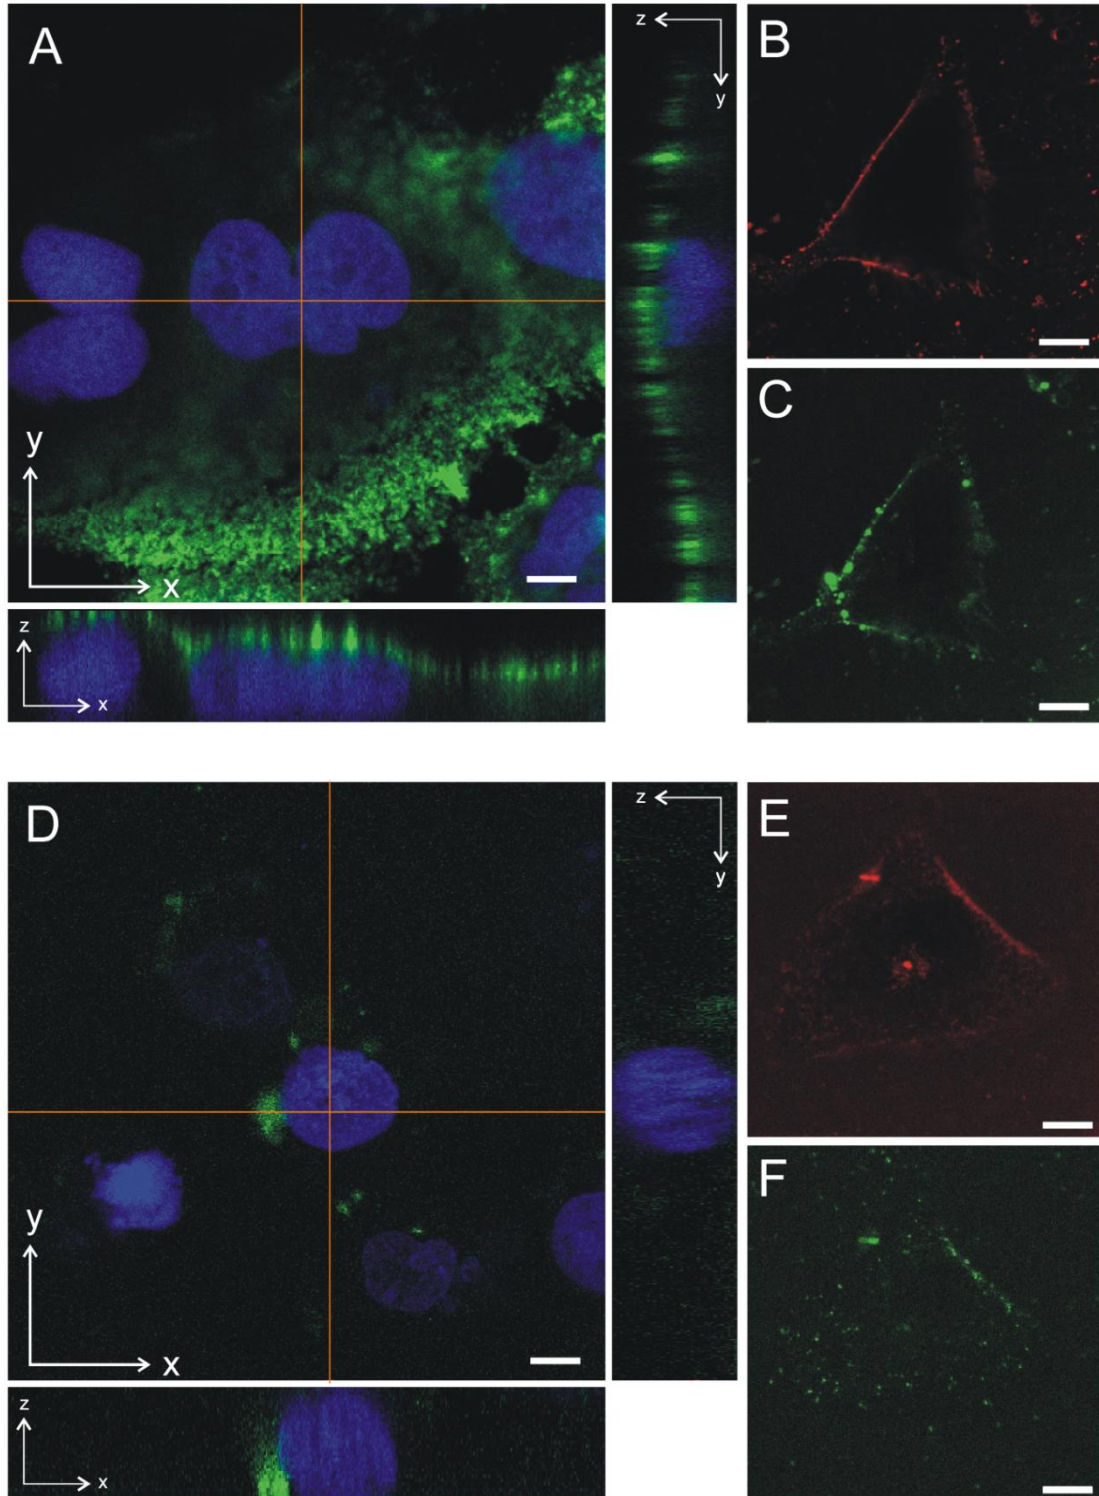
Cellular uptake and intracellular distribution of PEG-siPlexes (A till C) and ultrasound radiated PEG-siPlex loaded microbubbles (D till F). All PEG-siPlexes contain 5 mol% DSPE-PEG₂₀₀₀-biotin. Images A and D display confocal images and z-scans, at the positions indicated by the red lines, through HuH-7 cells with DraG5 labelled nuclei (blue) and incubated for 20 minutes with Atto488-labelled siPlexes (green). Confocal image (B) and (E) show the localisation of TRITC-concanavalin A (red), a plasma membrane marker. Confocal image (C) and (F) show the localisation of Atto488-labelled siPlexes (green) in the cells shown in image (B) and (E), respectively. The scale bars represent 10 μm .
